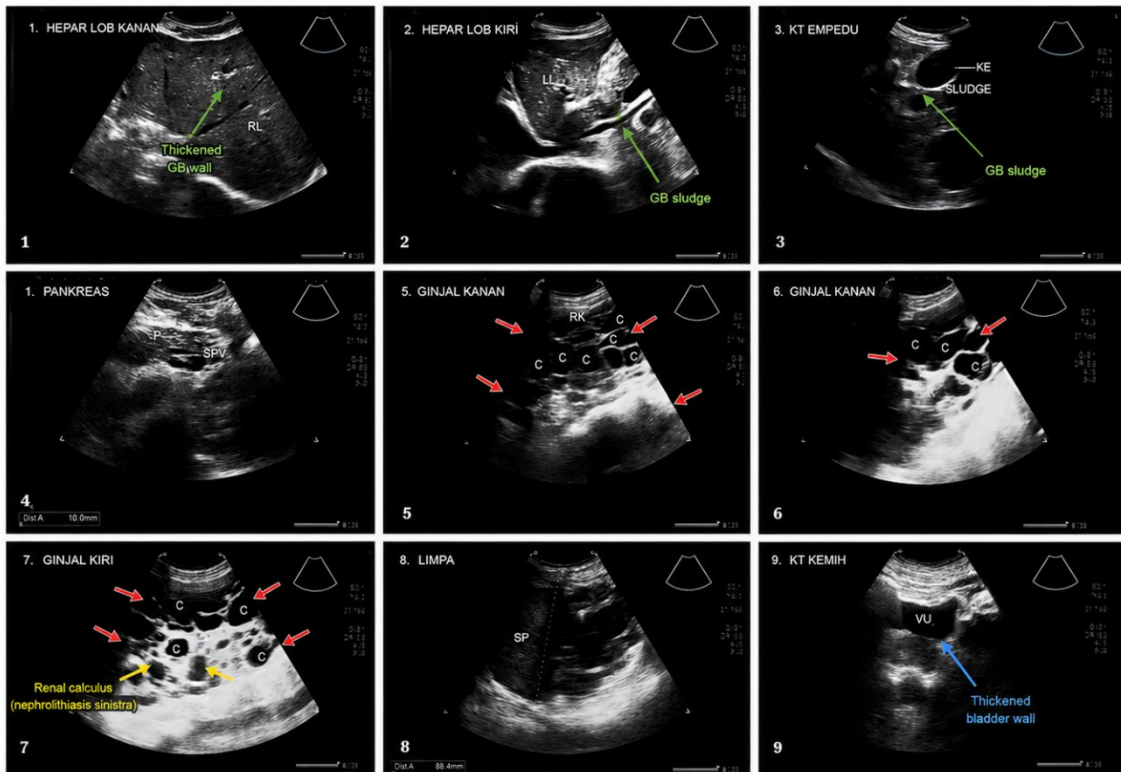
Ultrasound findings revealed left sided positioning of the liver and gallbladder with multiple cysts in both kidneys
